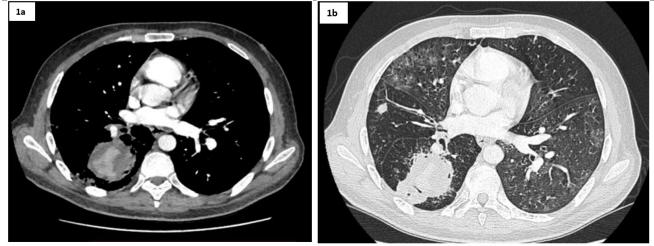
Axial thoracic CT angiography, mediastinal window (after injection of PDC) and lung window, showing extravasation of the contrast product in the right Fowler (1a), surrounded by excavated consolidation (1b), also associated with ground-glass lesions associated with alveolar hemorrhage
